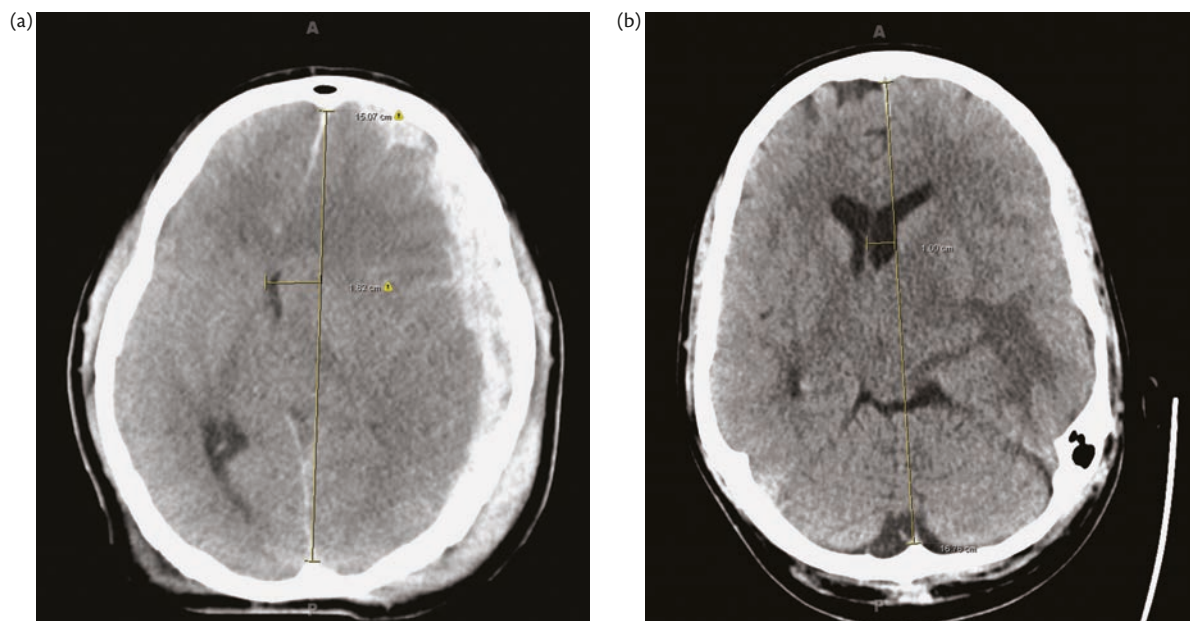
(a) Non-contrast head CT of a 58-year-old patient with an acute left-sided subdural haematoma with resultant 1.8 cm of midline shift at the septum pellucidum—this patient had a GCS of 3. (b) Non-contrast head CT of a 67-year-old patient with a left-sided glioma with 1 cm of midline shift at the septum pellucidum—this patient had a GCS of 15.
